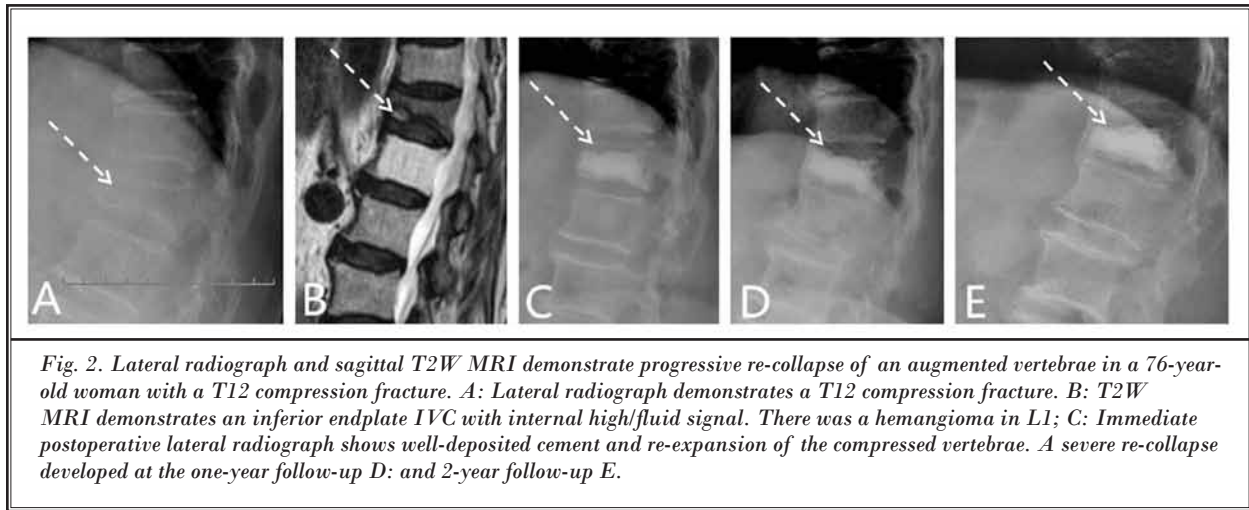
Lateral radiograph and sagittal T2W MRI demonstrate progressive re-collapse of an augmented vertebrae in a 76-year-old woman with a T12 compression fracture. A: Lateral radiograph demonstrates a T12 compression fracture. B: T2W MRI demonstrates an inferior endplate IVC with internal high/fluid signal. There was a hemangioma in L1; C: Immediate postoperative lateral radiograph shows well-deposited cement and re-expansion of the compressed vertebrae. A severe re-collapse developed at the one-year follow-up D: and 2-year follow-up E.
